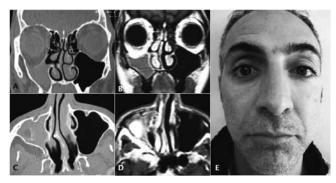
Preoperative A) CT image in coronal plane shows opacity of the right maxillary sinus, downward displacement of the orbital floor with a septal spur narrowing the right nasal fossa. The ethmoid sinus is not involved. B) T1 weighted MR image in coronal plane shows complete opacification of the right maxillary sinus with retraction of the orbital floor into the sinus. C) CT in axial plane shows inward bowing of the posterior wall of the maxillary sinus with enlargement of the retroantral fat pad. D) MR in the axial plane: right maxillary sinus shrinking and retroantral fat enlargement, signal hyperintensity due to orbital fat herniated at the level of maxillary sinus. E) Frontal view of the patient, notice right enophthalmos with deepened superior orbital sulcus.
